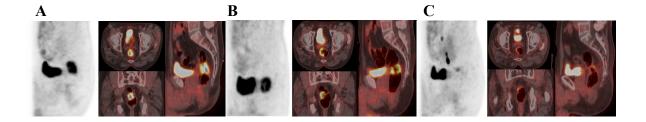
¹⁸F-FDG FDG-PET/CT images in a patient with incomplete pathological response. (A) Baseline ¹⁸F-FDG uptake in a cT3 lesion (TLG 57.6). (B) Early slight decrease in tumor TLG (TLG 48.38; ΔTLG-early 16%). (C) Late near complete disappearance of the tumor (TLG 8.06; ΔTLG-late 86%). Pathological analysis showed incomplete pathological response (ypT3N1, TRG3). Pelvic recurrence and death occurred after 35 and 53 months from initial treatment, respectively
